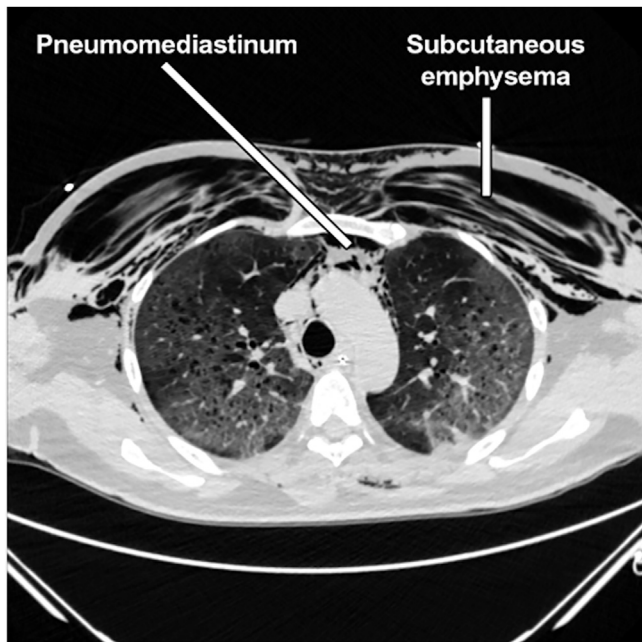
Computed tomography image demonstrating pneumomediastinum and severe subcutaneous emphysema in patient with COVID-19.
